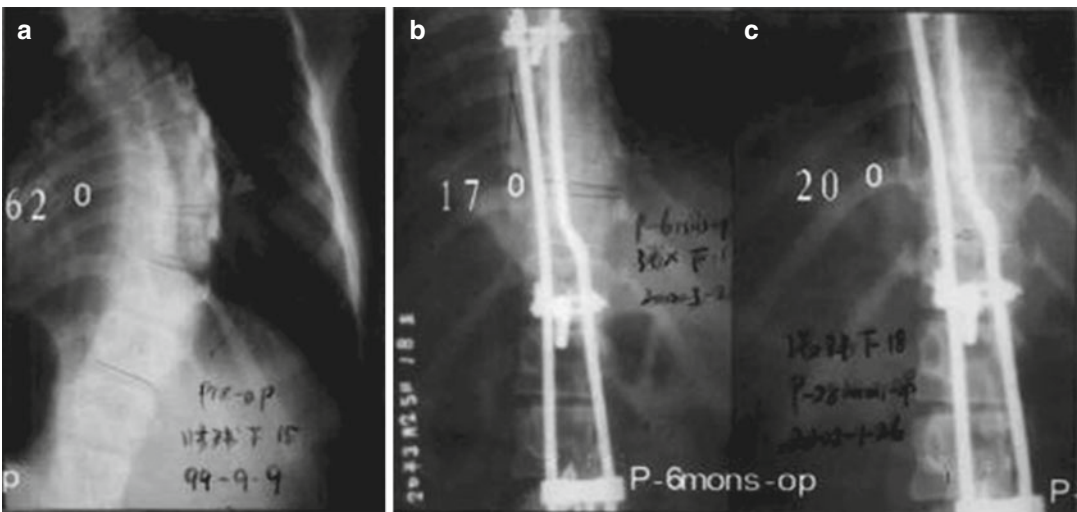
Preoperative radiograph shows disc spaces open up on the convex side and close up on the concave side all along the apical region (a), which is reversed on both side after PRSS was applied (b). Another A–P view
